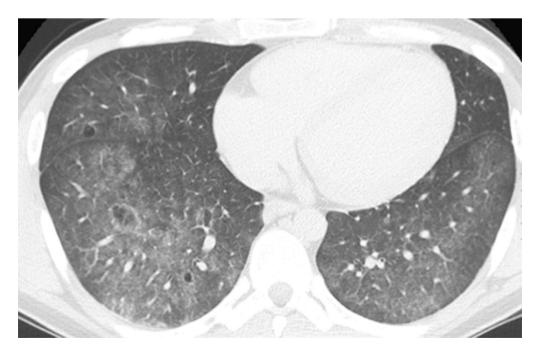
Chest CT showing diffuse patchy ground-glass opacities and cysts
